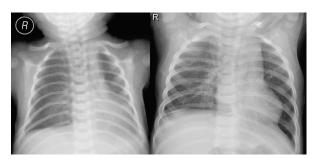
Follow-up chest radiographs postoperatively at 2 weeks (left) and at 8 months (right) show normal ventilation of the left lung.
